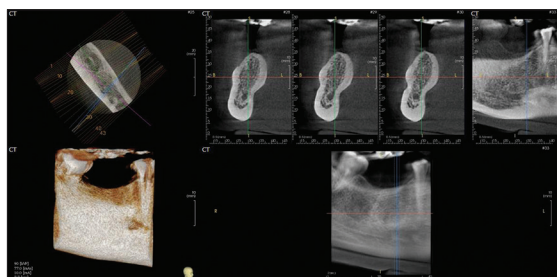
Preoperative cone beam computed tomography field of view
